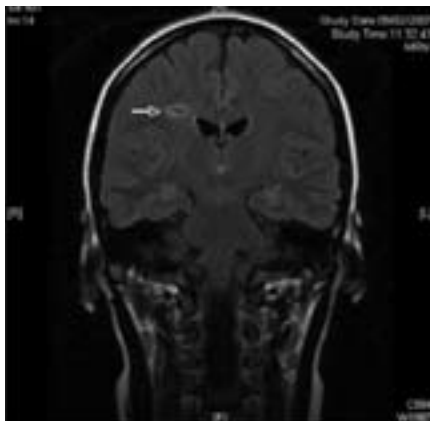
(b): T1-weighted MRI brain coronal showing cavitating lesion in right hemisphere (white arrow).
